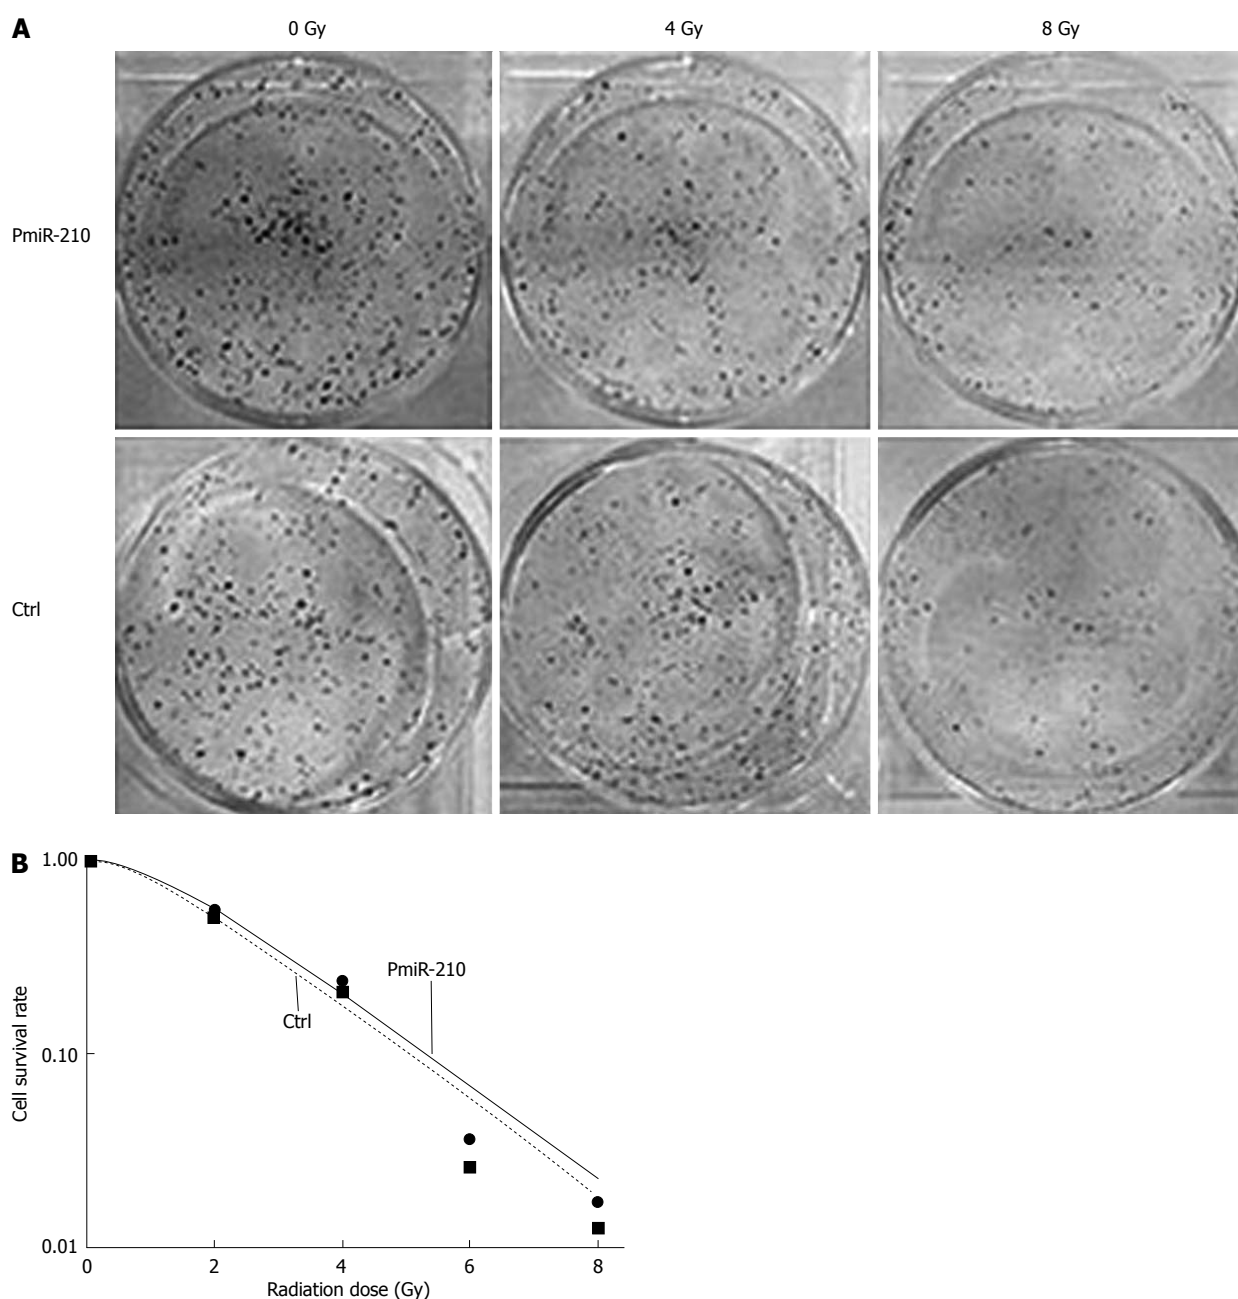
MiR-210 reverses the radioresistance of TE-1R cells. A: Clonal formation of TE-1R cells that were transfected with the miR-210 mimic (pmiR-210) or with a nonsense sequence (Ctrl) after irradiation at 0, 4 or 8 Gy of 10 mV X-rays. The experiments were performed in triplicate; B: Cell survival curve for TE-1R cells that were transfected with the miR-210 mimic (pmiR-210) or with a nonsense sequence (Ctrl). The cell survival rates were plotted on a logarithmic scale.
